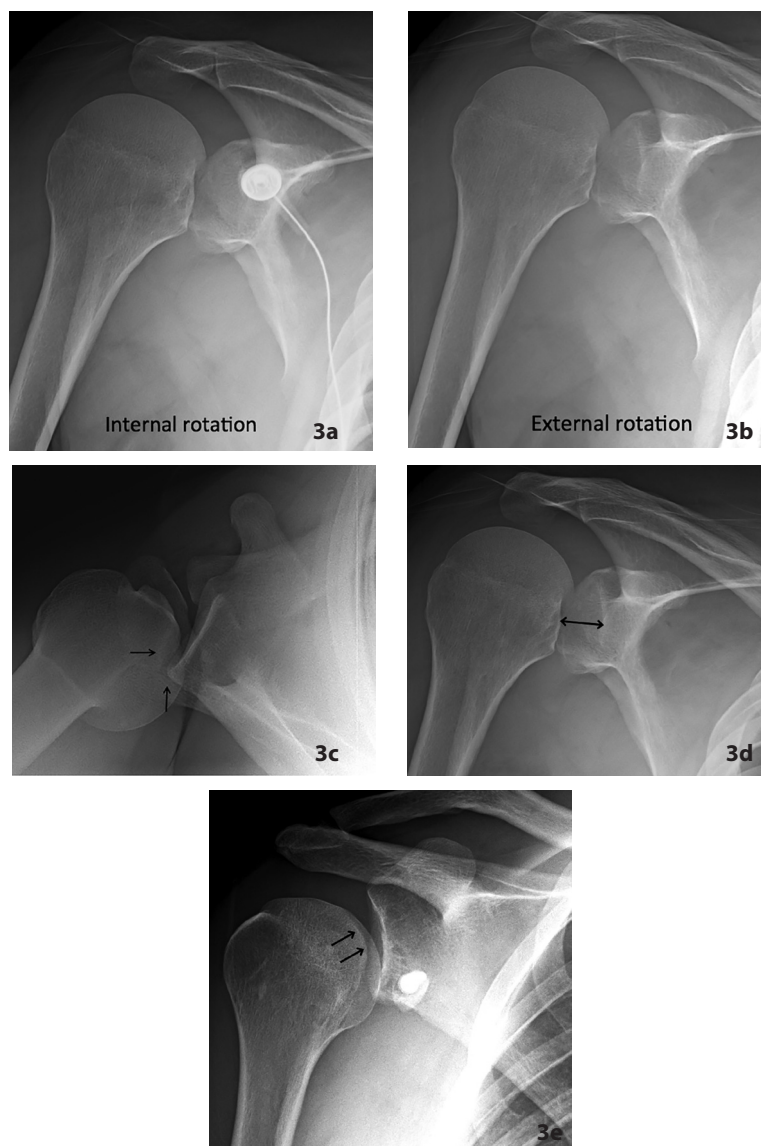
Classic radiographic findings of posterior shoulder dislocation. In (a) AP internal rotation and (b) attempted AP external rotation radiographs of the right shoulder, the humeral head remains in fixed internal rotation on both imaging projections. (c) Axillary radiograph of the right shoulder in a different patient shows an impaction fracture at the anteromedial aspect of the humeral head (arrows) consistent with a reverse Hill-Sachs lesion. In (d), internal rotation AP radiograph of another patient, note a widened glenohumeral joint space (arrow) measuring 1.8 cm with inadequate overlap between the humeral head and glenoid. (e) AP radiograph of the right shoulder in another different patient shows a vertical line of cortical bone projecting over the superomedial aspect of the humeral head (arrows) corresponding to the trough line sign created by the margin of the humeral head impaction fracture. Surgical hardware projects over the inferior glenoid from prior screw fixation.
